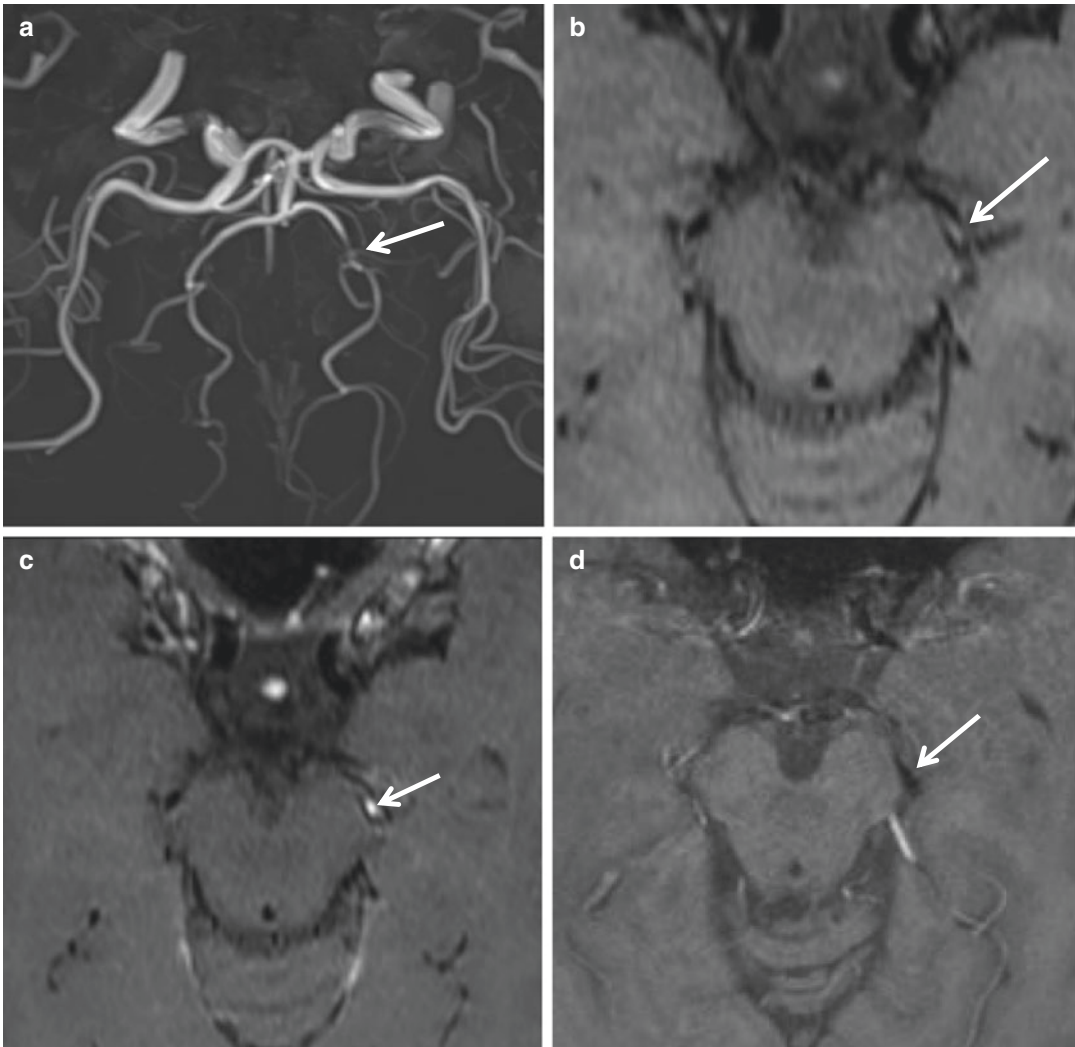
A 65-year-old woman had head injury after falling down. She had headache and dizziness and 5 days later developed transient tingling sensation in the right face and limb. Neurological examination was normal, and brain MRI did not show any abnormality. MRA showed a focal stenosis in the P2 portion of the left posterior cerebral artery (PCA) (arrow, a). High-resolution vessel wall
